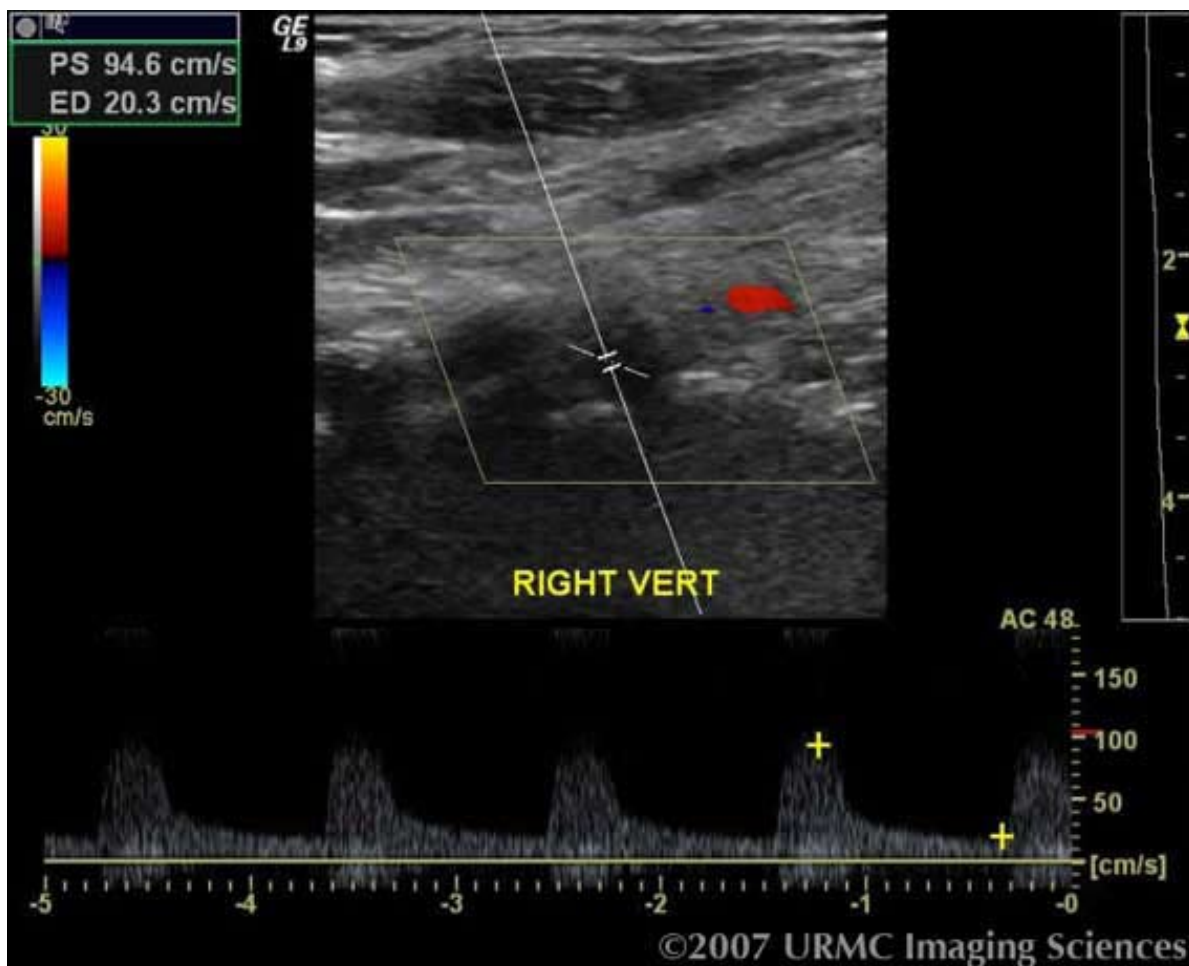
Color duplex ultrasound with signal from the right vertebral artery shows a high resistance wave form with antegrade flow.
